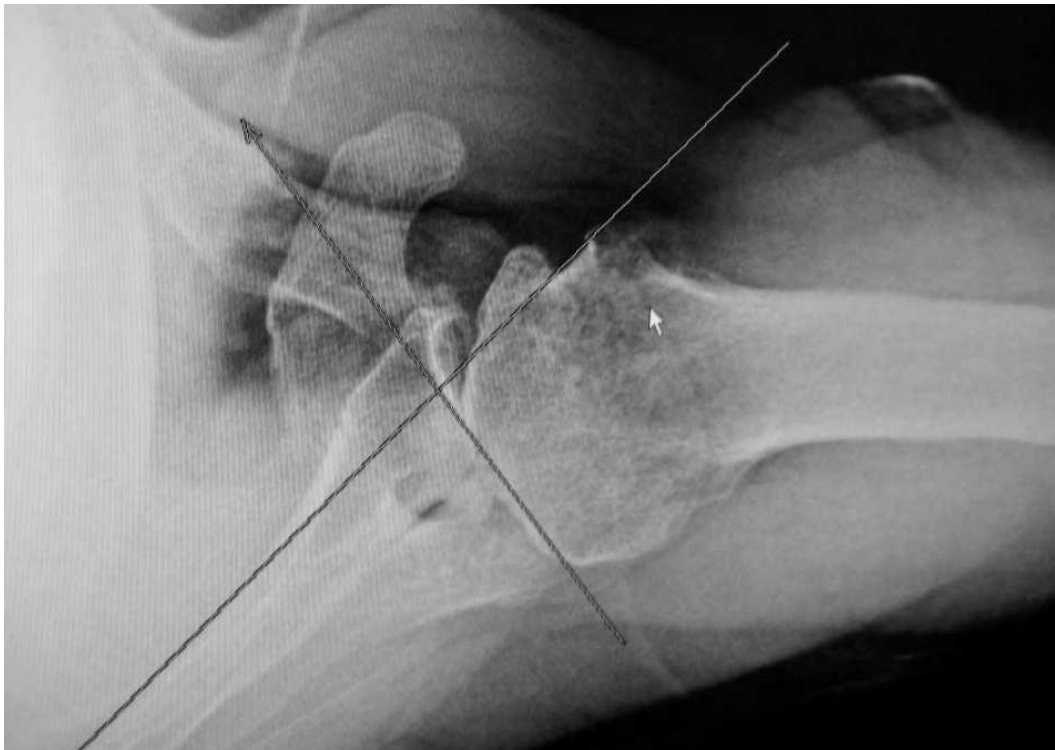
Axillary lateral radiograph showing double concavity, posterior glenoid erosion and posterior humeral subluxation. Preoperative planning can determine the degree of corrective reaming needed to restore proper glenoid orientation relative to the axis of the scapula
